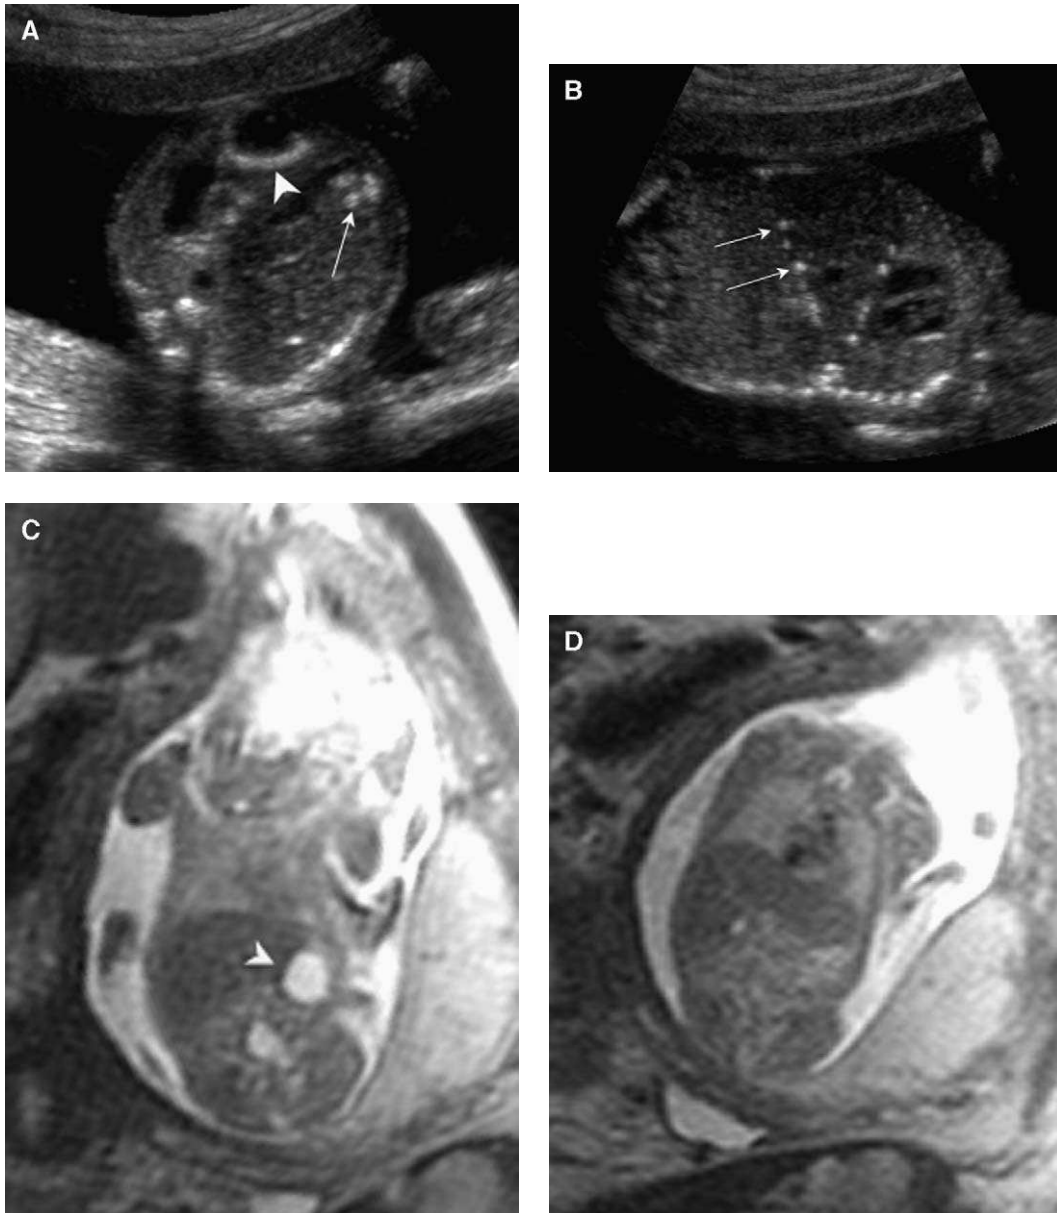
US (A,B) and MR imaging (C,D) in a fetus with a meconium pseudocyst (*arrowheads*) and intraabdominal calcifications (*arrows*) at 19 weeks' gestation. Whereas the pseudocyst is well visualized on MR imaging, the punctate calcifications are not visualized.
